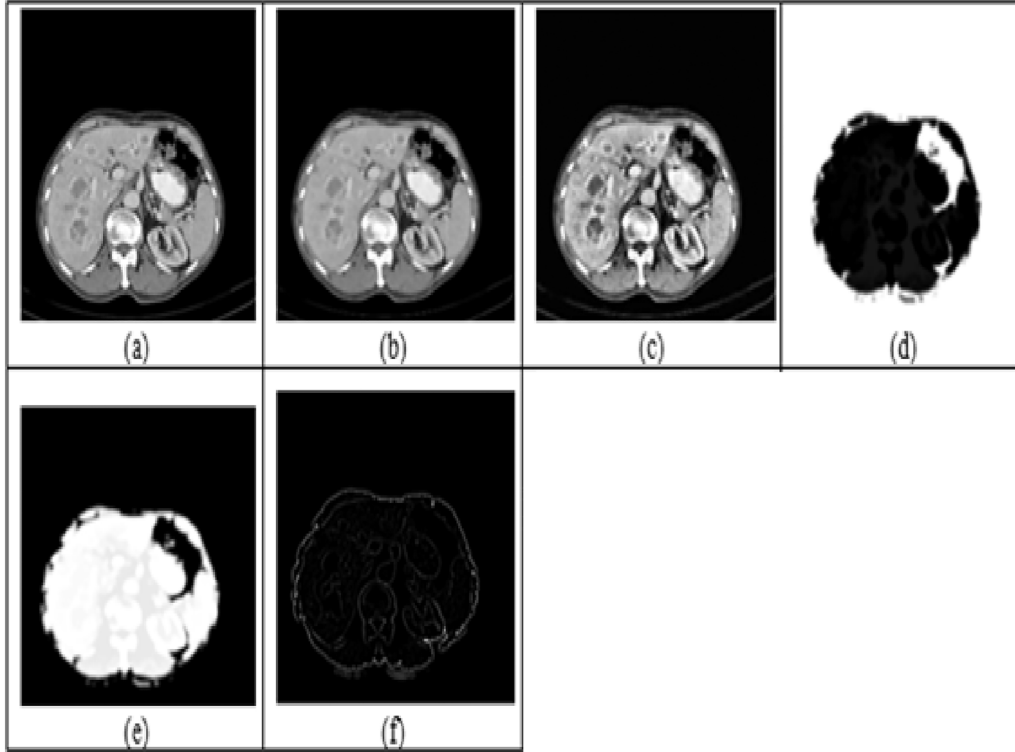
The results of neutrosophic sets for liver CT image segmentation. (a) Original image, (b) image after applying median filter, (c) image after apply histogram equalization, (d) false Subset, (e) truth Subset, and (f) indeterminate Subset.
